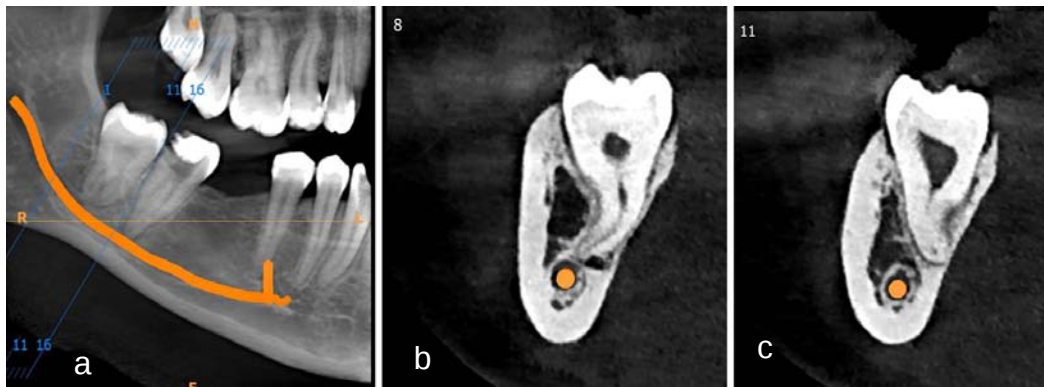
CBCT images show a vertically impacted lower right third molar. In the panoramic image, the roots have a favorable curvature and appear conical (a). However, the cross-sectional images clearly display a severe bucco-lingual curvature. The distal root is buccally curved (b), whereas the mesial root possesses a lingual curvature and is in close proximity to the lingual cortical plate (c).
